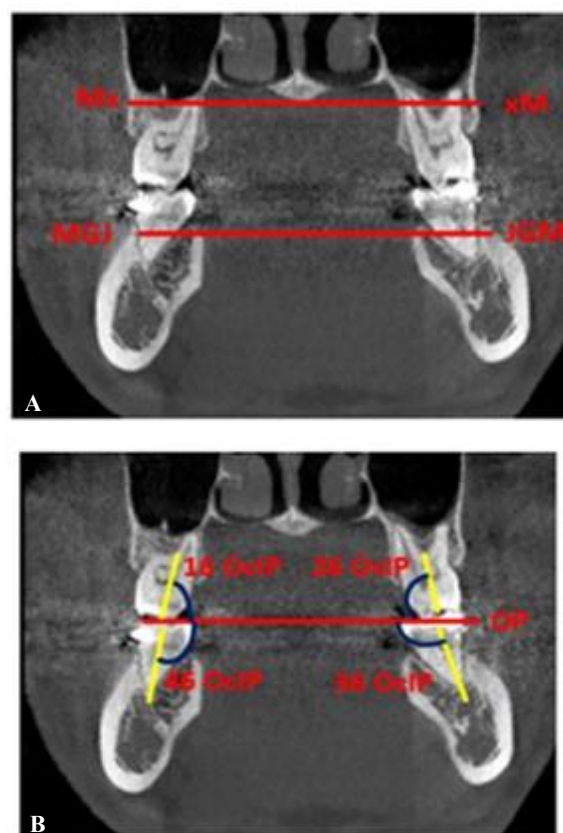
(A and B): CBCT method for evaluation of molar inclination with occlusal plane. Reproduced from Vasquez JM, Escobar AFPC, Loyo IF, Cano PAS.
